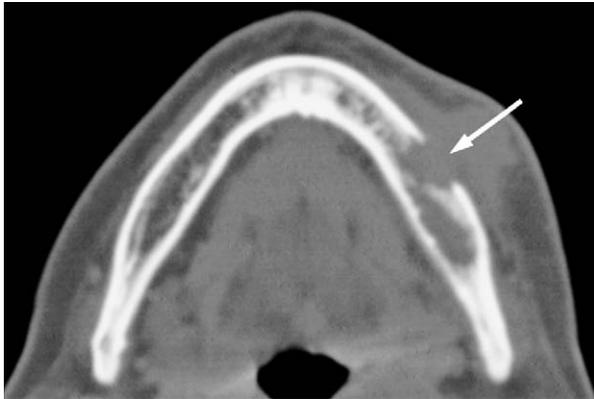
An axial CT image of a bacterial osteomyelitis case shows cortical bone perforation (arrow). The remaining cortical bone has almost normal density.
